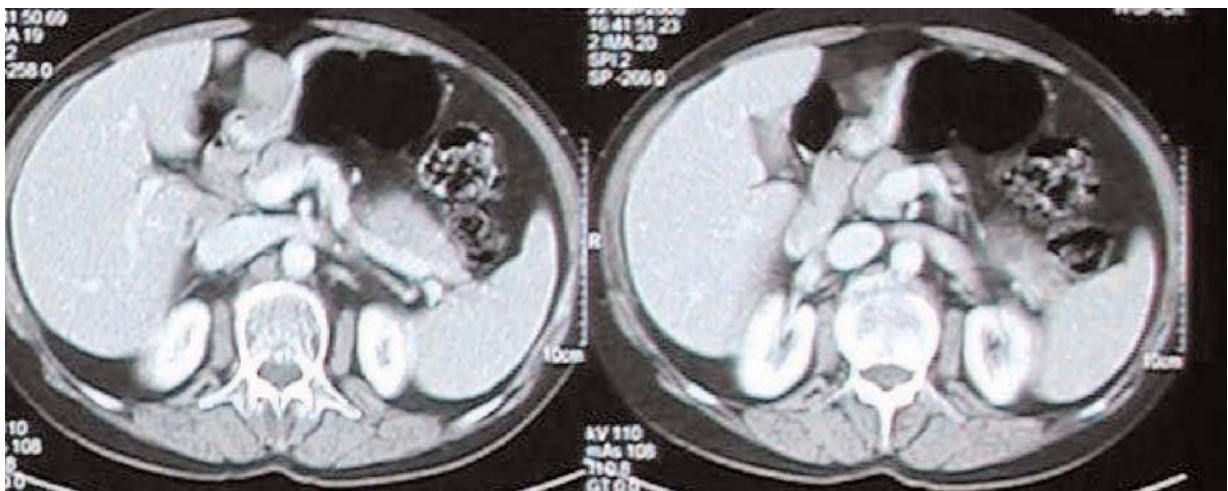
Computerized tomography scanning of the upper abdomen demonstrating an oval shaped, well defined soft tissue mass (30×35mm) originating from the anterior wall of the antrum. Because of the submucosal origin of this soft tissue mass an endoscopic ultrasonography (EUS) was performed in order to obtain a tissue sample for pathologic diagnosis.
